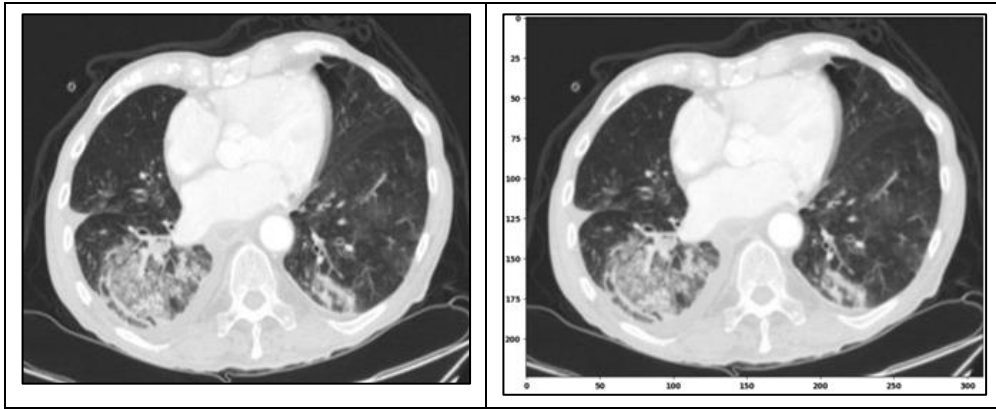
The selected CT scan of lung in good health (left) and the image after scaling (right)
